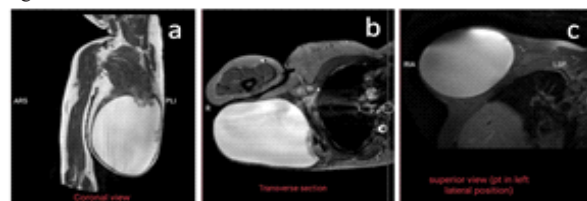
(a) Coronal view, (b) Transverse view, (c) Superior view of MRI right axilla showing of large thin wall cystic lesion involving subcutaneous and intermuscular plane region and appears hyperintense on T2-weighted images.
